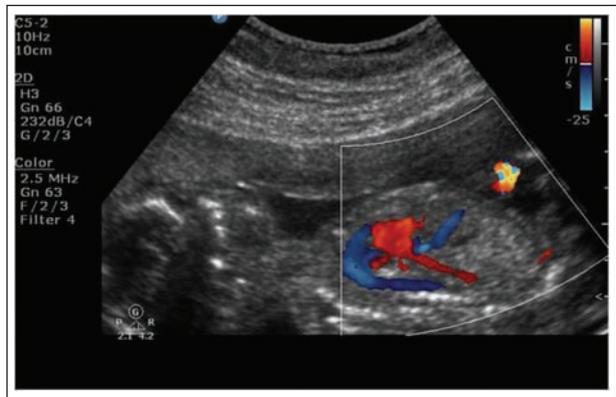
Color Doppler used to confirm the type of persistent right umbilical vein (PRUV) according to its drainage. Arrow, PRUV.
